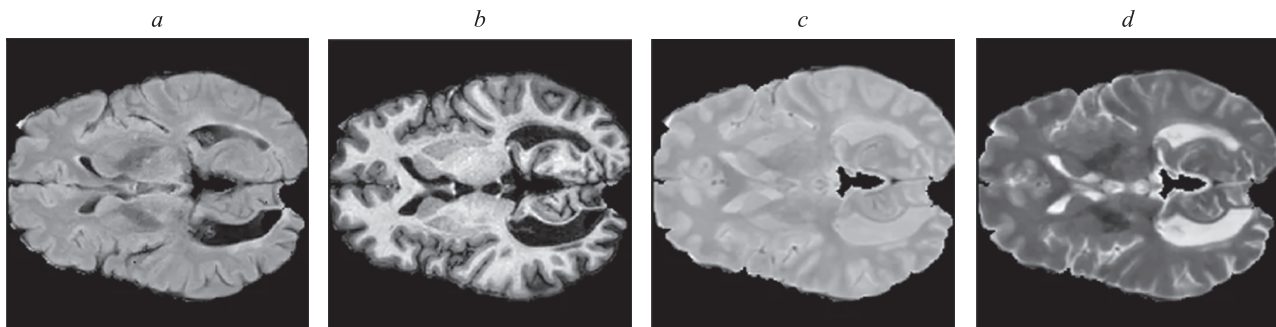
MRI images with different imaging methods: T1-Weighted Image (*a*), T2-Weighted Image (*b*), FLAIR Image (*c*), PD-Weighted Image (*d*)
